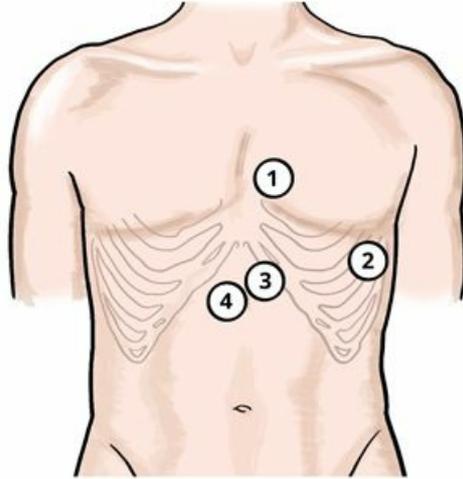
Ultrasound probe positions for the basic FAST exam.
